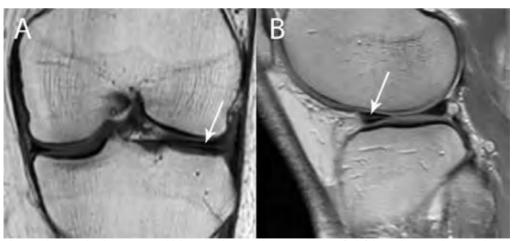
MRI images of a horizontal meniscus tear
